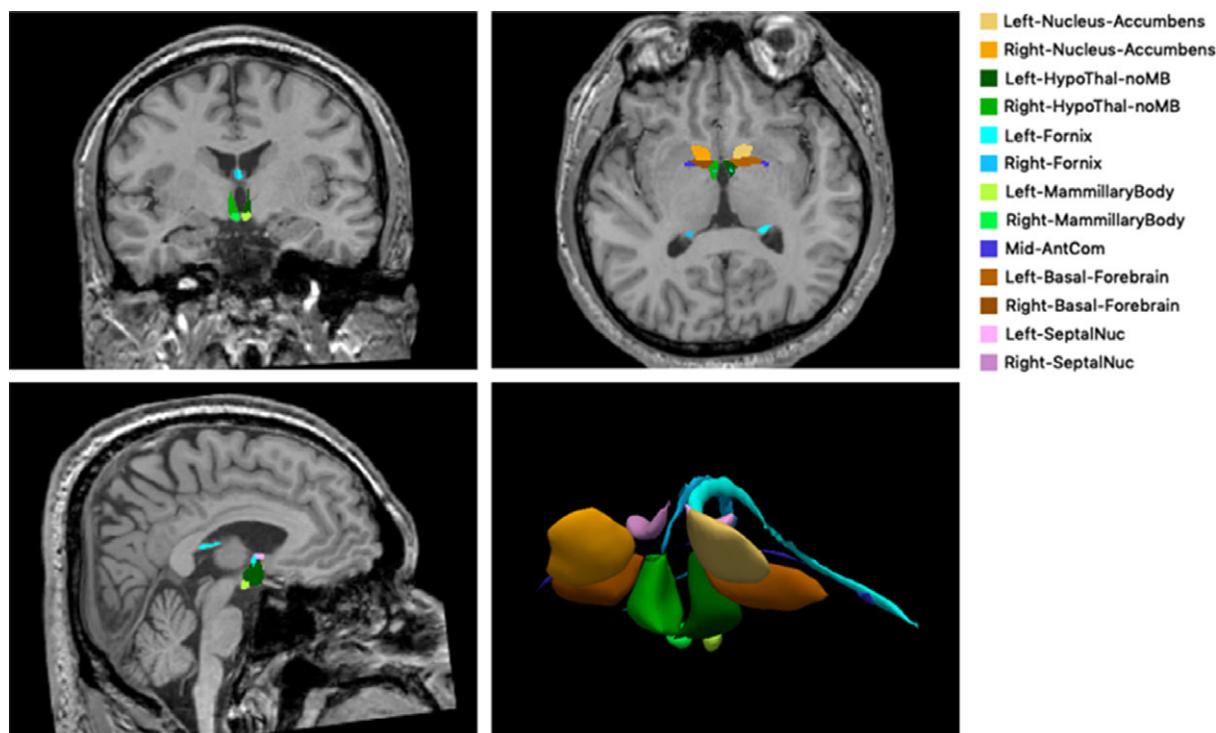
The example of segmentation of subcortical limbic structures. The segmentations are overlaid onto a T1-weighted image in coronal, axial, and sagittal orientation and shown in volume rendering. HypoThal-noMB: hypothalamus, AntCom: anterior commissure, SeptalNuc: septal nucleus.
